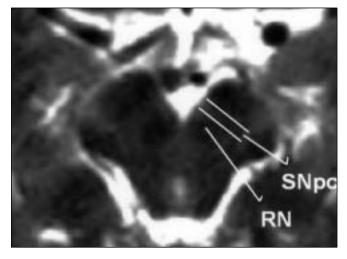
T2-weighted axial midbrain image of a patient. RN: Red nucleus, SNpc: Substantia nigra pars compacta with relatively high signal intensity between the red nucleus and pars reticularis
